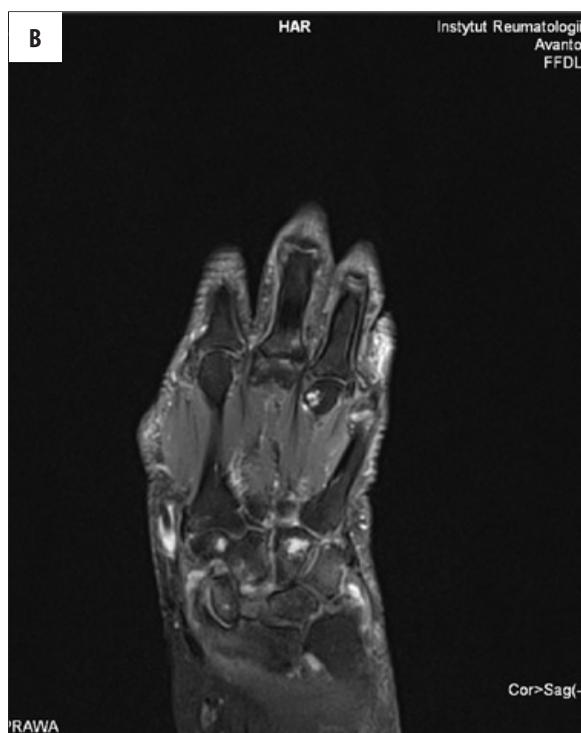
MRI examination, images in the frontal plane in (A) T1, (B) PD FS, (C) T1 FS CE image: increased signal of varied size within the endosteum and subchondrium, in the carpal and midcarpal bones.
